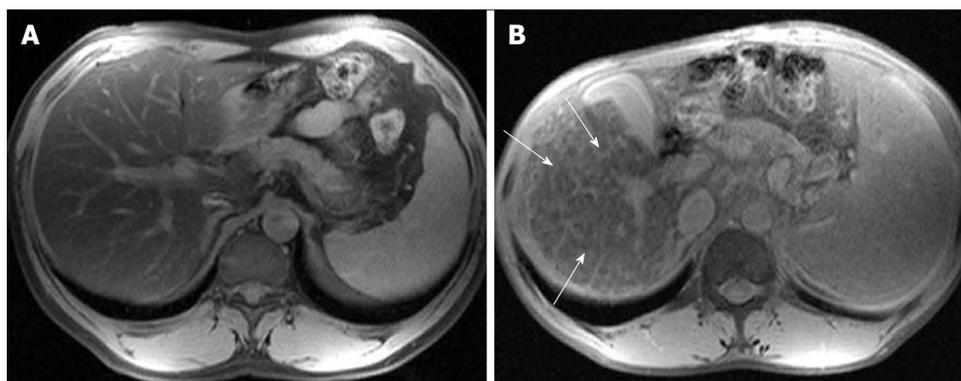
Double contrast enhanced protocol magnetic resonance images. Fat saturated T2-weighted magnetic resonance images of 15-min delay after injection of superparamagnetic iron oxides and gadolinium chelates. A: The image of normal patient shows homogenous low signal intensity of hepatic parenchyma; B: The image of patient with liver cirrhosis shows hyperintense reticulations (arrows), represent septal fibrosis, in cirrhotic liver.
